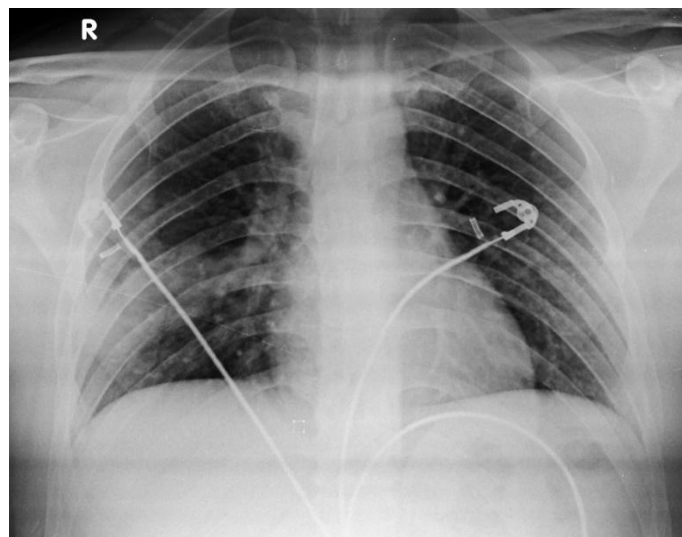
Frontal chest radiograph of the 23 year old male patient with haemoptysis which revealed large fairly well defined lobulated soft tissue opacity in the right mid zone with a tail like extension into the right hilar region not silhouetting the cardiac margins. No calcifications seen. No obvious cardiomegaly or abnormal pulmonary vascular markings seen.
